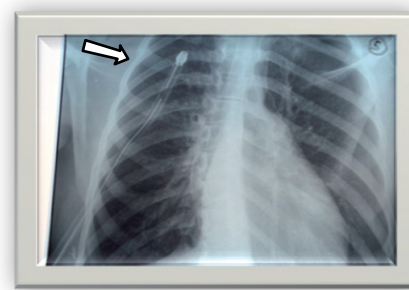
Chest radiography showing the thoracic drain inserted in a reexpanded right lung.
